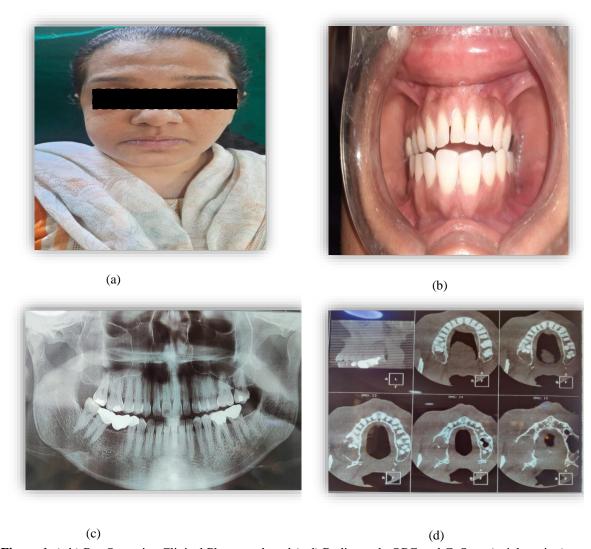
(a,b) Pre-Operative Clinical Photograph and (c,d) Radiograph, OPG and Ct Scan (axial section)
